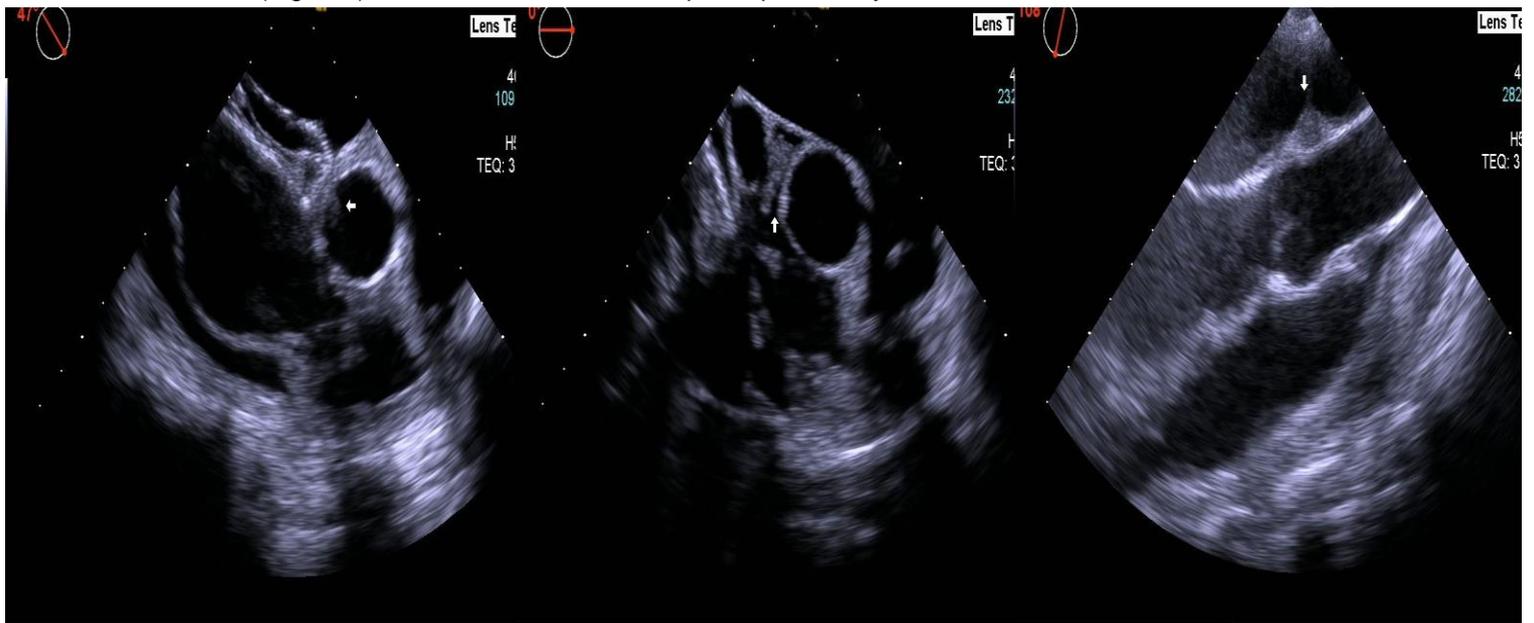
Echocardiography views showing clot around aorta (arrows) and pericardial effusion.
